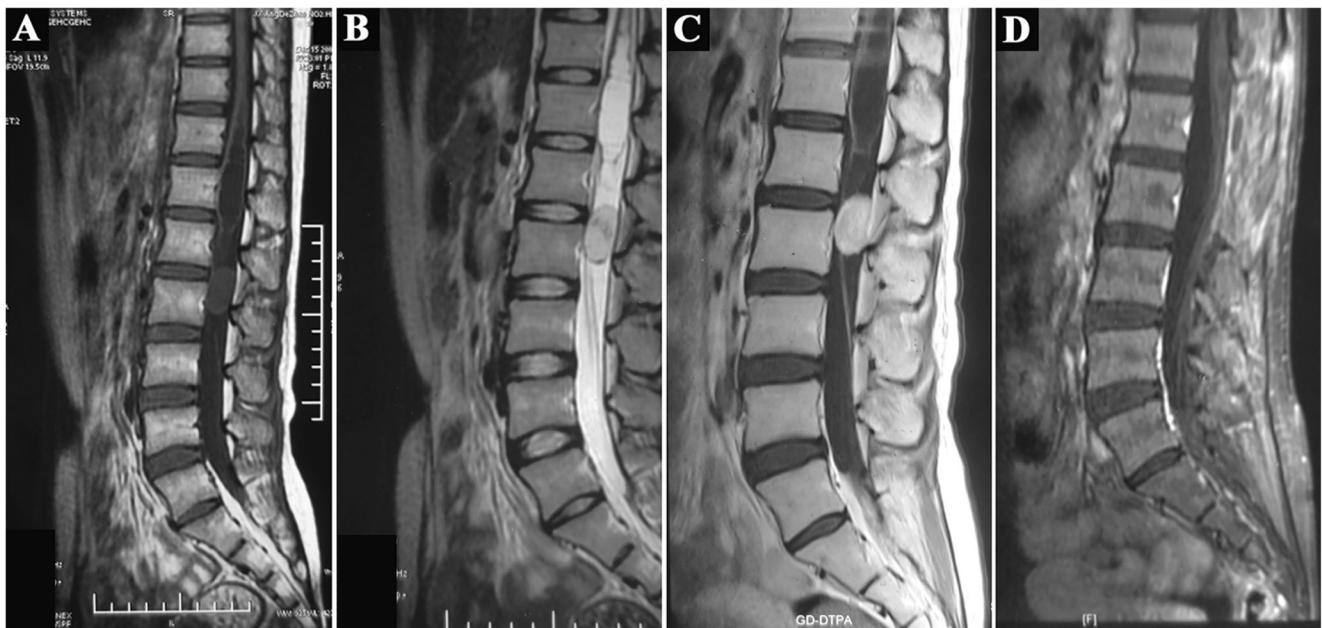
Sagittal MRI showing an intramedullary mass at the L1–2 level, with syringomyelia at the T10–L1 level. a T1-weighted image showing an isointense lesion. b T2-weighted image showing a hyperintense lesion.
